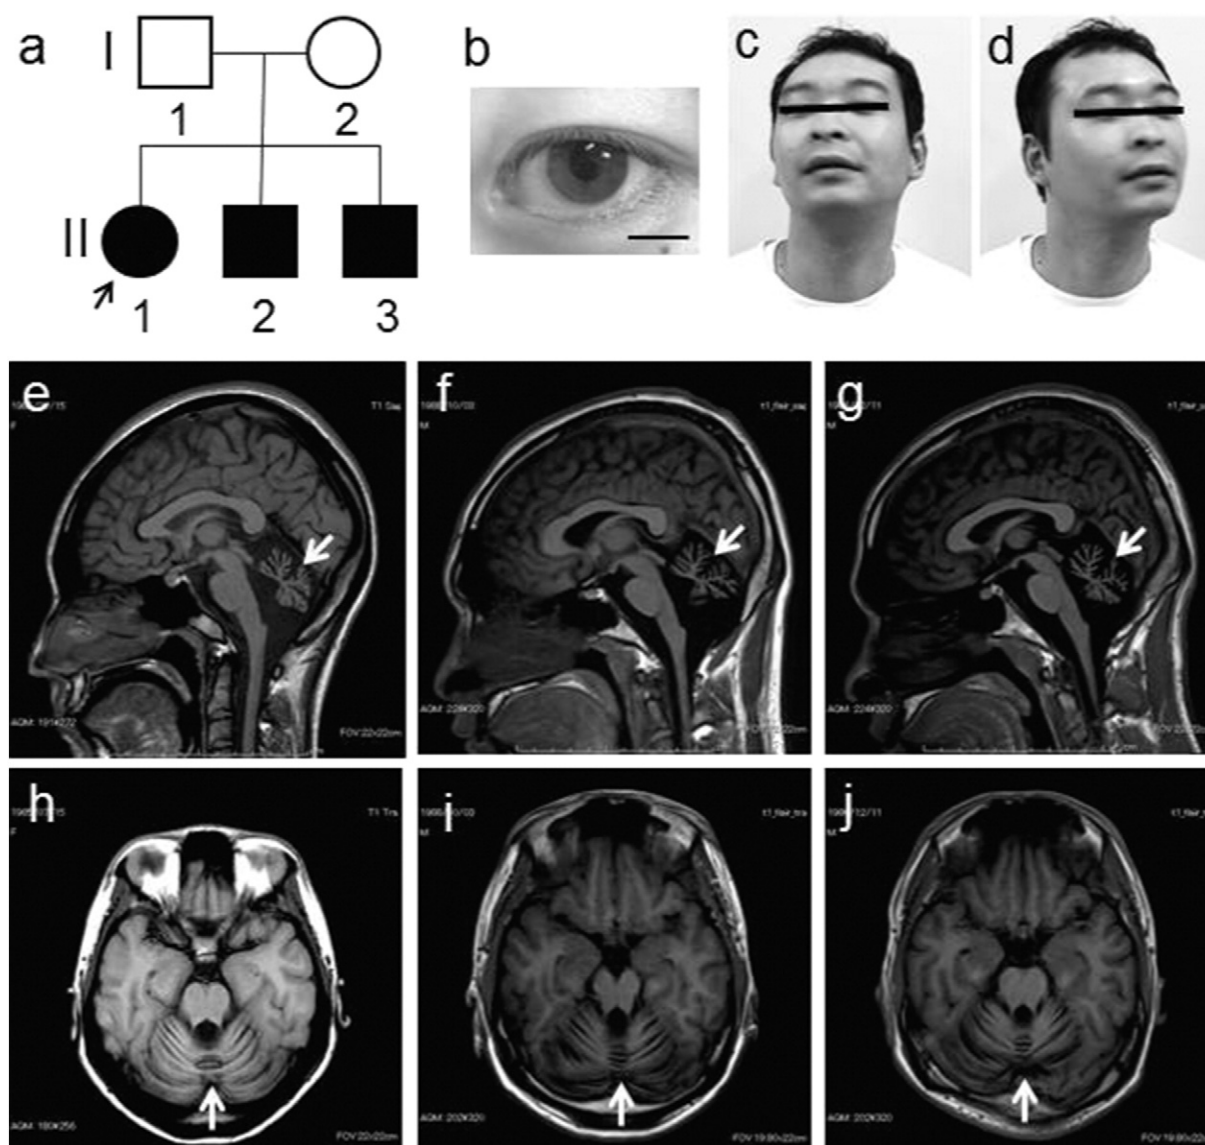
(a) Family tree of the patients. (b) Photograph of mydriasis (lt. 7.5 mm) in case II-1 (scale bar = 10 mm). (c, d) Photographs showing involuntary head movement (2–3 Hz) of case II-3. (e–j) Magnetic resonance images (MRI) showing vermian dominant cerebellar atrophy (arrows) of patients II-1, 2, and 3.
